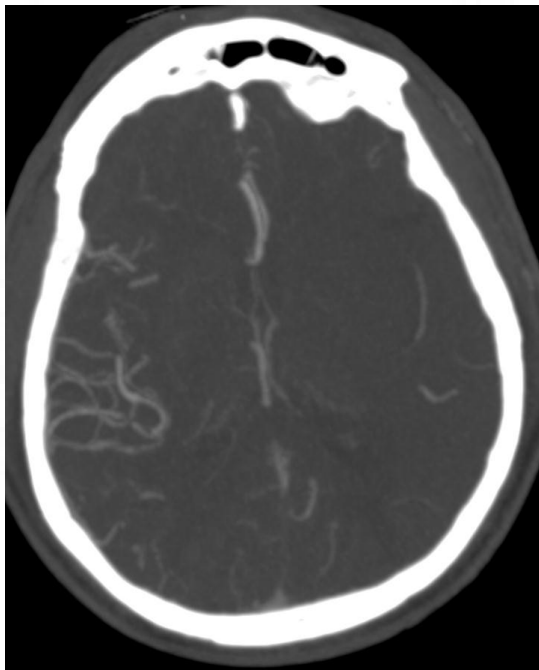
Axial CT MIP single phase showing poor collateral score (TAN grade 1)
